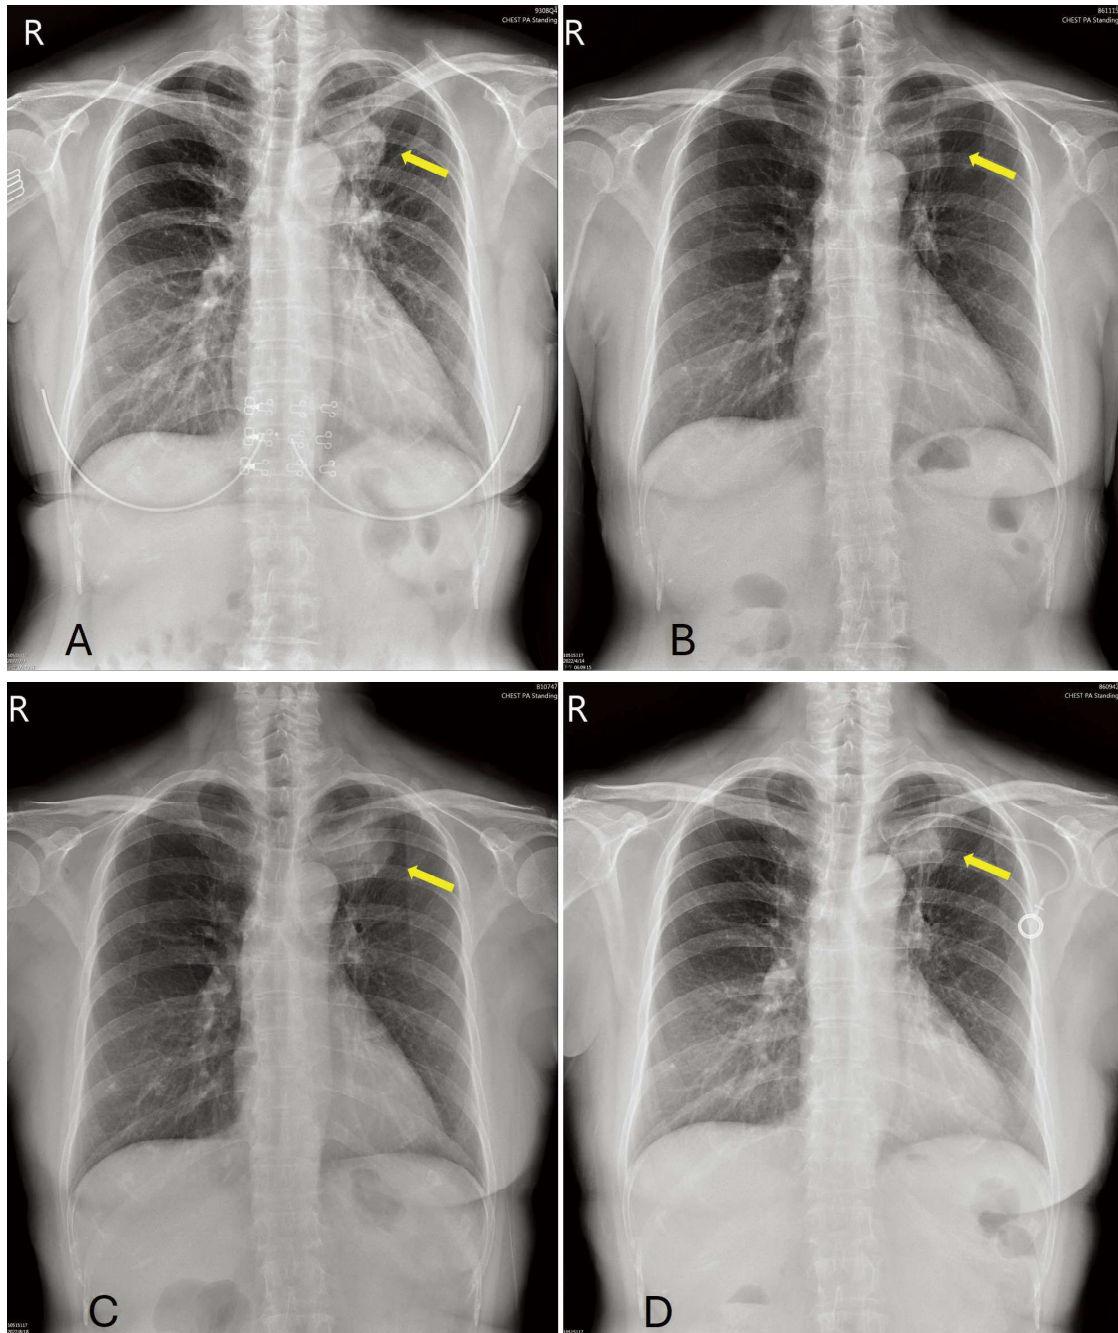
Chest X-ray showing (A) Baseline adenocarcinoma (B) Partial remission after 2 months of afatinib treatment (C) Recurrent LUL tumor after treatment for 6 months, and (D) Tumor size shrinkage after 1 month of chemotherapy with cisplatin plus etoposide, and afatinib treatment.
